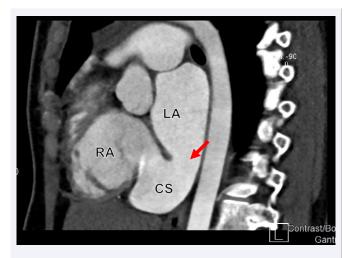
Cardiac computed tomography angiography (CCTA) in sagittal display showing a communication between the RA and LA representing unroofed CS (Arrow). CS, Coronary Sinus.
